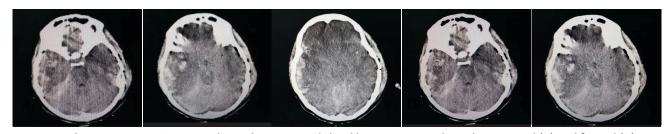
The non-contrast CT scans showed an acute subdural haematoma in the right temporal (B) and frontal (A) area and a hemorrhagic contusion (C), a right temporal and sulcus effacement in the right temporal and parietal regions with right uncal herniation with diffuse brain ischaemia (D) and brain stem infarction due to hypoxia (E)
